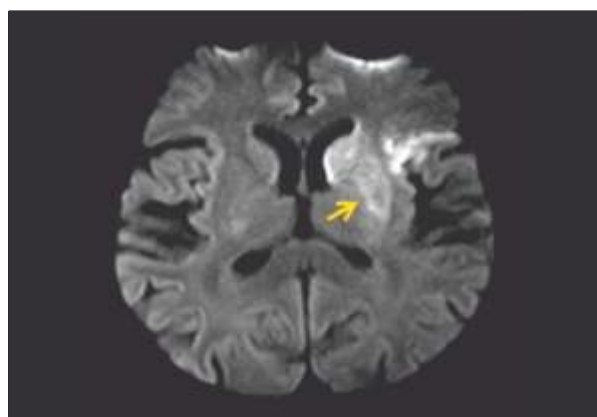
Axial Diffusion weighted MRI image shows hyper acute infarct involving the left basal ganglia and adjacent cortex (anterior insula) Fig 1b - TOF MR angiography of the neck vessels show occlusion of the left internal carotid artery from origin with no flow in the left middle cerebral artery territory.
